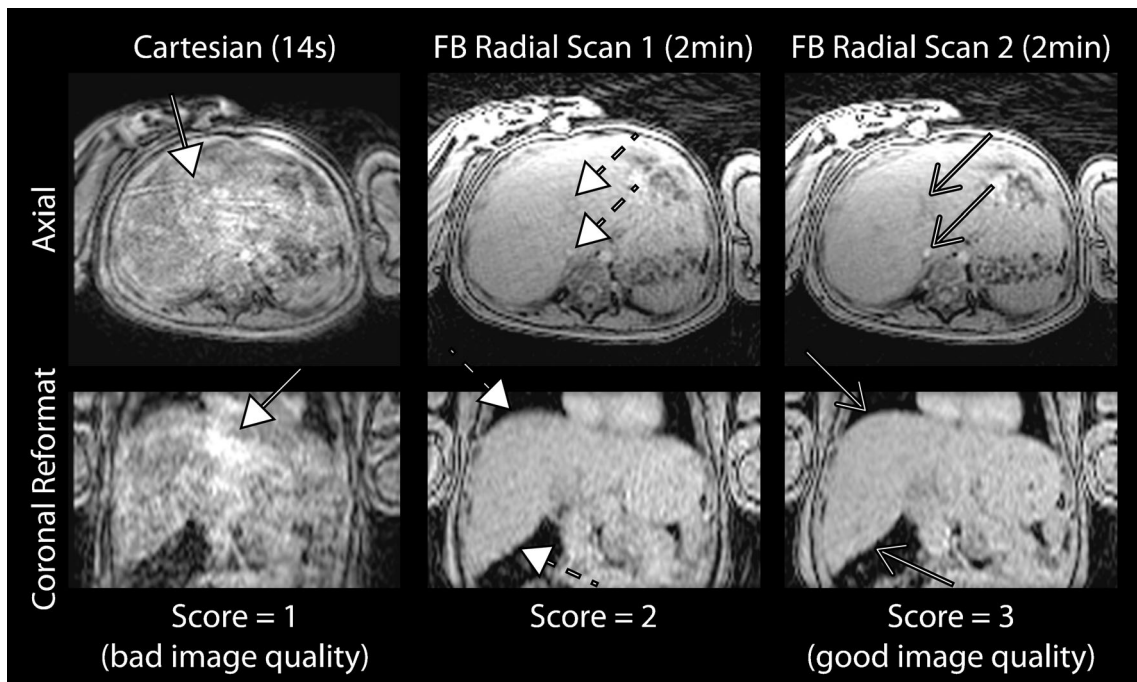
Representative Cartesian and free-breathing radial infant abdominal MR images from subject 3, a 6.4-month-old girl. These examples have image-quality scores of 1–3. A score of 1 represents non-diagnostic images (i.e. bad image quality), a score of 2 represents diagnostic images with minor motion artifacts in the liver, and a score of 3
